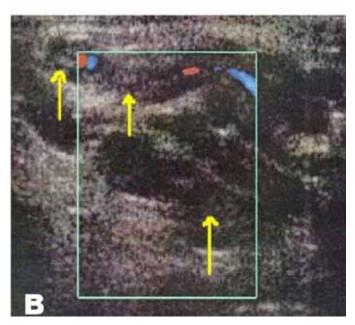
(A, B) Doppler ultrasound showing echogenic intraluminal thrombus in the dilated pampiniform plexus (yellow arrows).
